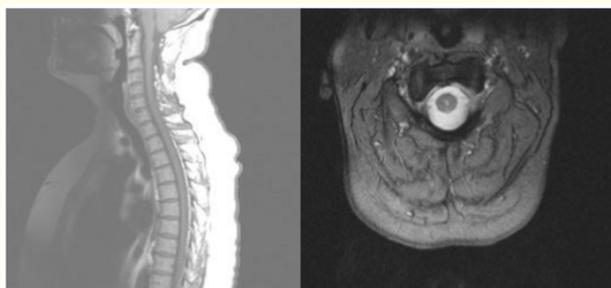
Postoperative images in sagittal and axial sections of T1 and T2-weighted magnetic resonance imaging showing complete excision of cystic lesion behind C2 posterior to the cord with no evidence of residual.
